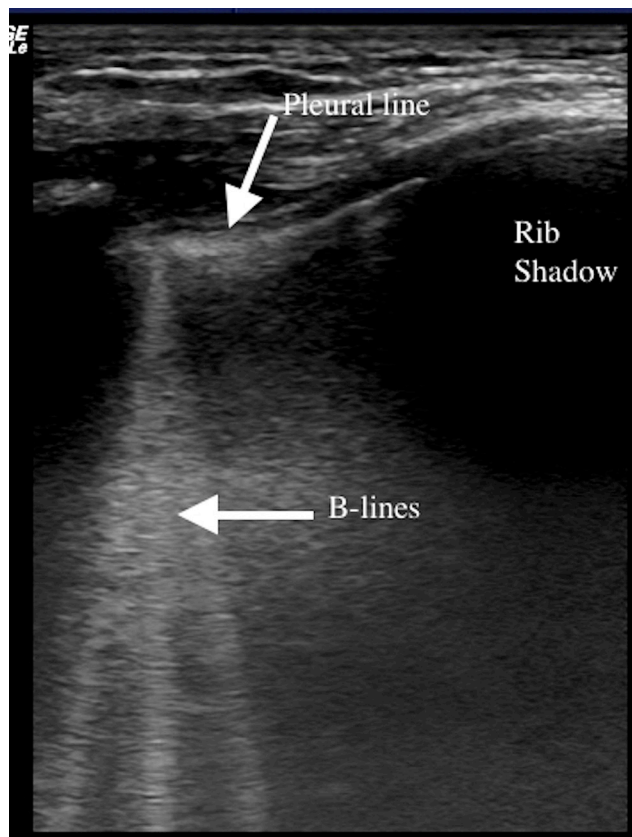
A lung ultrasonography scan of a single intercostal space showing B-lines (white vertical lines)—curved array.¹³
